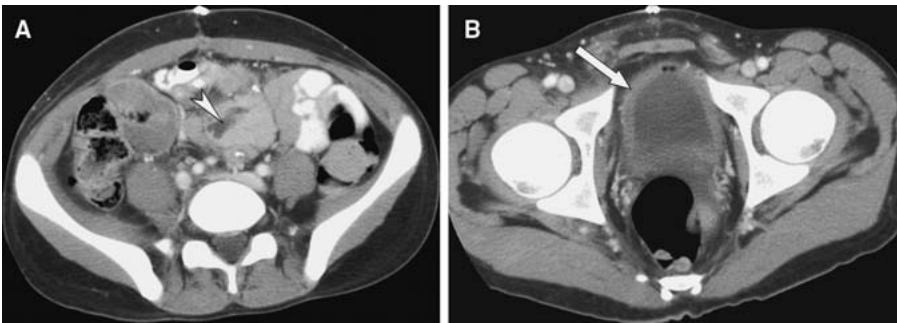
A Axial contrast-enhanced CT of the lower abdomen in a 20-year-old male shows pancreatic duct dilatation (*arrowhead*). There was no clinical pancreatitis at 15-month follow-up. B Pelvic image in the same patient shows diffuse wall thickening of the urinary bladder (*arrow*). This is almost
